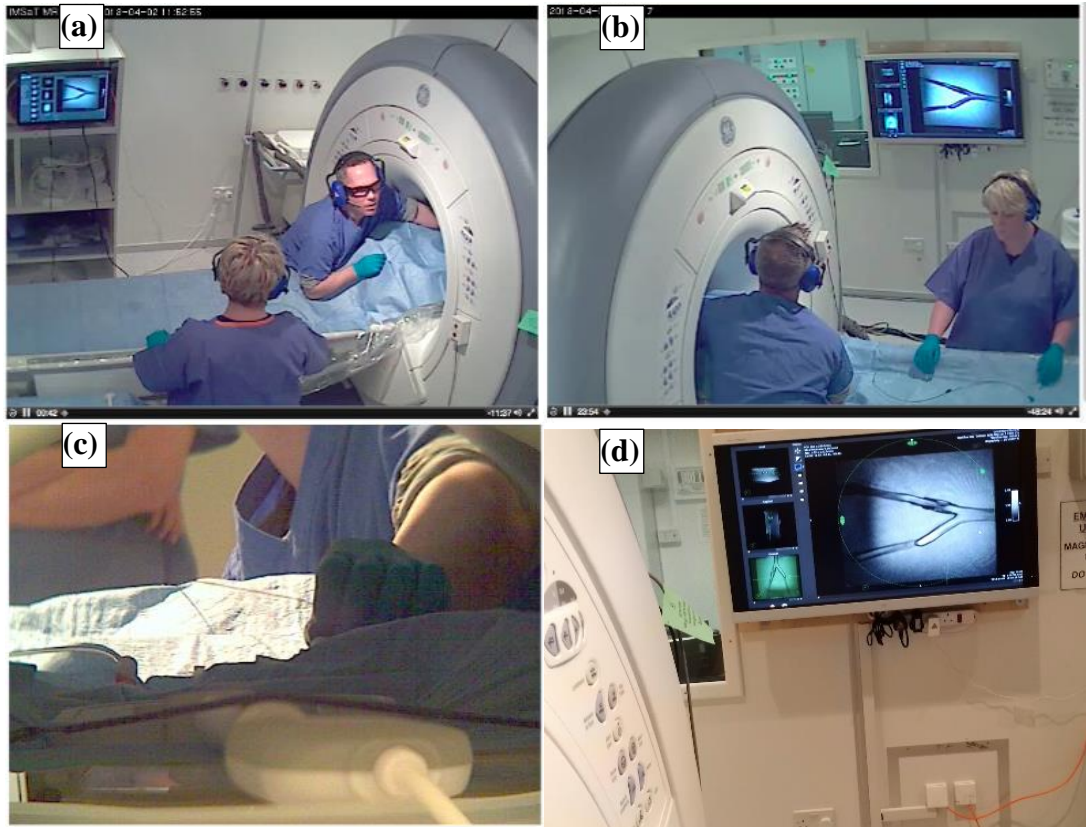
Perspectives of the cameras arranged in the MRI suite during the interventions: (a) right, (b) left, (c) bore, (d) first-person.
